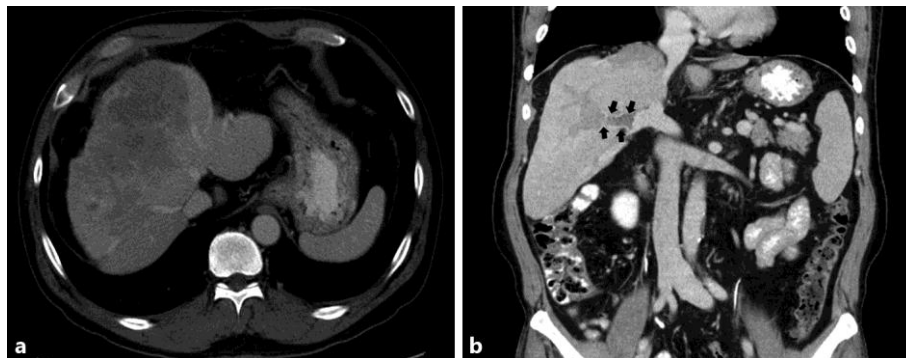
Dynamic liver computed tomography. a Low-density lesions without definite margin of massive infiltrating HCC involving segments 4 and 8 (11.3 × 9.0 × 7.8 cm) on the portal phase. Other small similarly patterned lesions were found on segments 7 and 8. b Total occlusion of the right portal vein by malignant tumor thrombosis (black arrows) was found on the coronary section.
